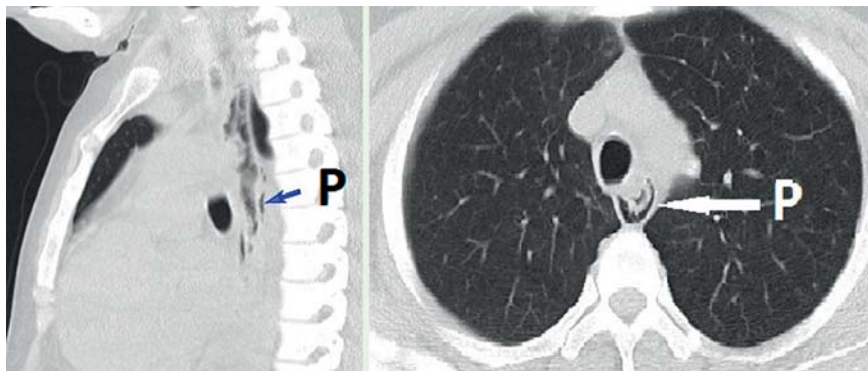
Thoracic computed tomography showing perforation (P) of the esophagus with extraluminal air next to the esophagus.
